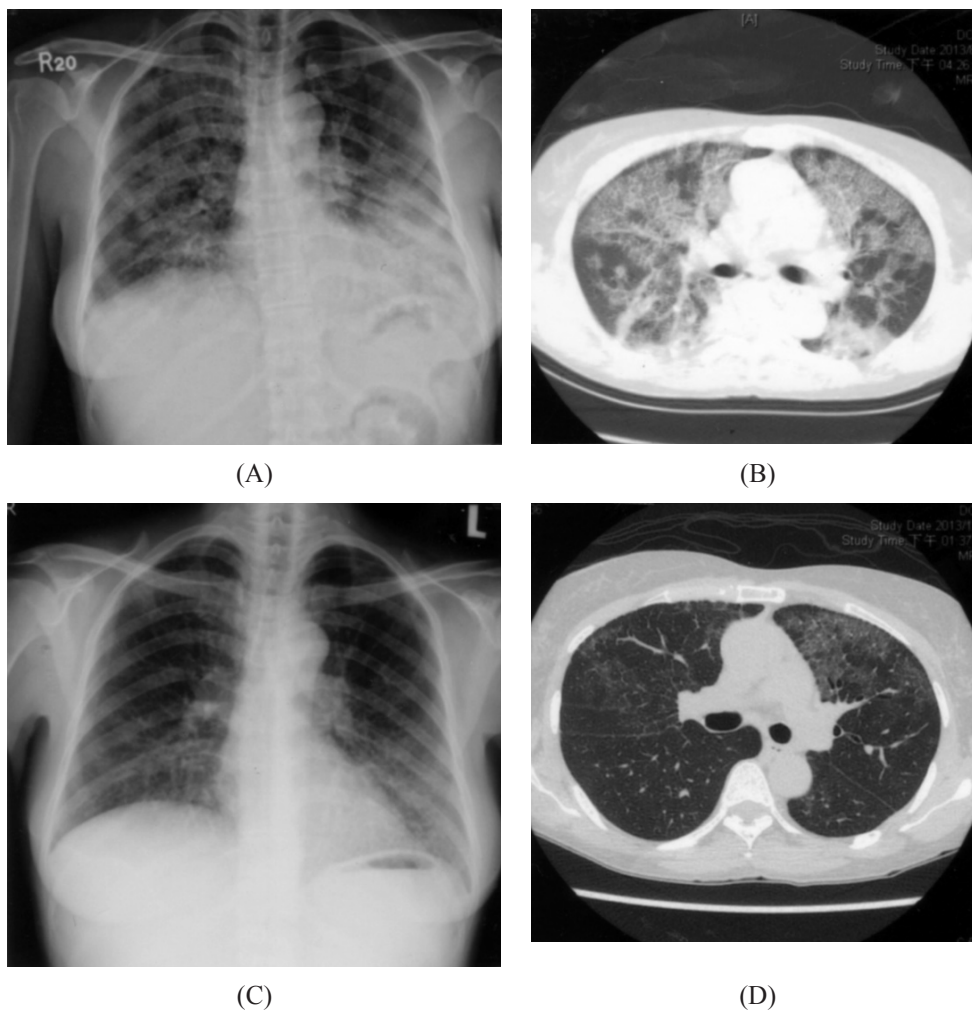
Chest radiography showing diffuse alveolar opacities before lavage (A); High-resolution CT scan of the chest showing the classic finding of widespread airspace consolidation with thickened interlobular septa (B); Decreased bilateral lung parenchyma infiltration on post-lavage day 13 (C); Improvement in widespread airspace consolidation with thickened interlobular septa on post-lavage day 53 (D).
